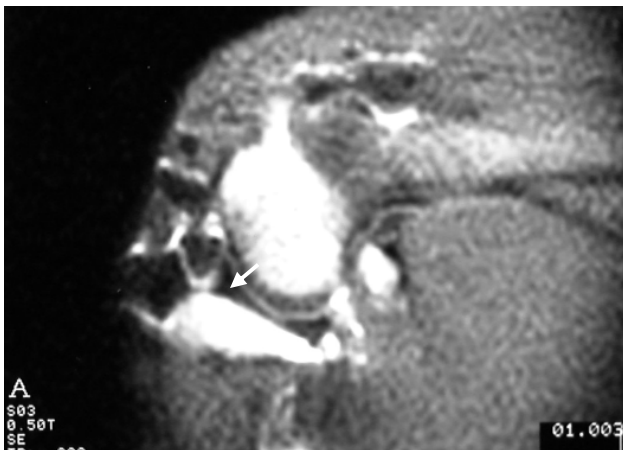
Partial discectomy with collagen template implantation: complete regeneration. Follow-up T1-weighted MR image (TR=300 ms, TE=20 ms) of left knee 8 weeks after partial meniscectomy (anterior horn) shows a homogeneous low signal intensity of the regenerative anterior horn of the meniscus (arrow). Note that no signal intensity difference of the regenerative meniscus as compared to the normal posterior horn of the meniscus.
